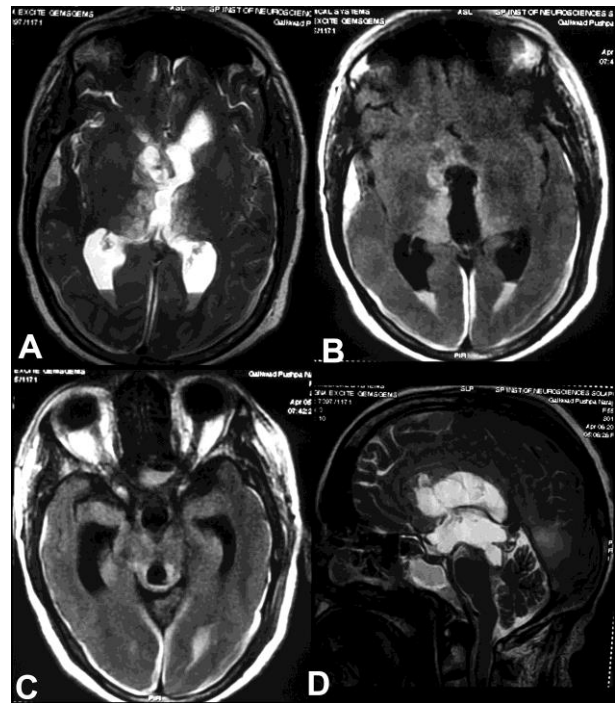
Post-operative MRI T2W and FLAIR axial images showing although the tumor could be removed from upper part of the aqueduct but still the lower part is closed.
